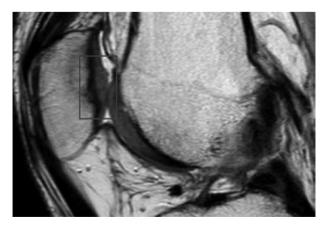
Sagittal proton-density- and T2-weighted turbo spin echo (TSE) image on 1.5 T MR unit. The black square shows an irregular subchondral bone plate with a hypertrophic aspect of the repair tissue.
